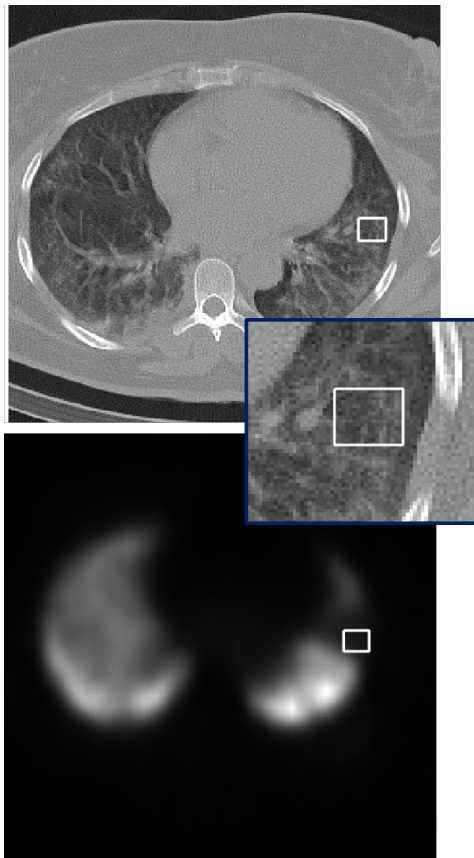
Example of COVID-19 pneumonia with PE. The top image shows the CT scan and the bottom one the SPECT perfusion scan with the region with COVID-19 pneumonia and PE inside the white square. A close-up in the CT scan of such region is shown in the middle image.
